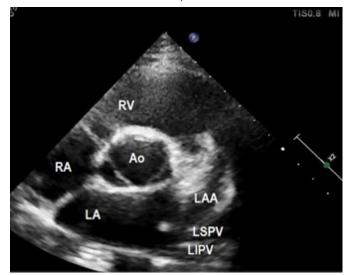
Parasternal short axis view. On the lateral wall of the left atrium 3 structures can be seen: the most anterior is the left atrial appendage with a large ostium; in close proximity to the LAA drains LSPV which has an anterior to posterior direction; LIPV drains in the posterior region of LAA having a posterior to anterior direction.
